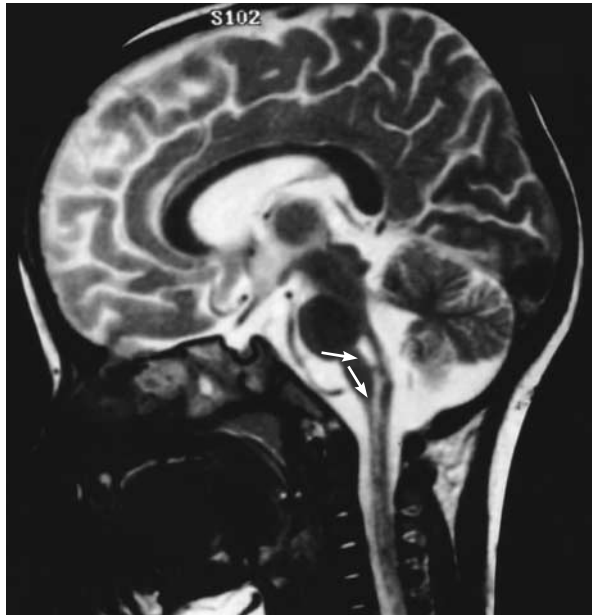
Midsagittal Spin-Echo T₂-Weighted MRI Scan Obtained in a Two-Year-Old Boy Two Months after the Onset of Grade III Rhombencephalitis Due to Enterovirus 71 Infection.
